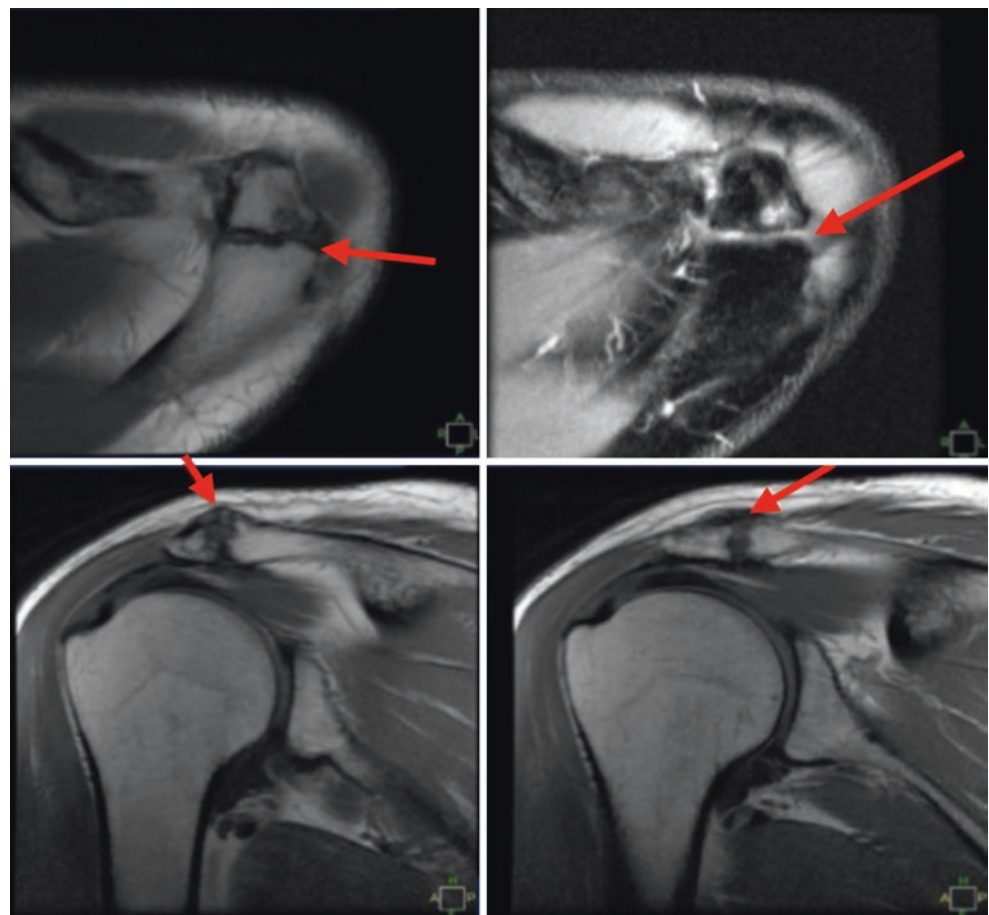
MRI left shoulder that shows an intact rotator cuff, healing of the previous SLAP repair, moderate AC joint osteoarthritis, and a meso-acromion with sclerotic changes and soft tissue swelling at the meso-acromion site. (Reproduced with permission from Stetson, W. B., Morgan, S., Chung, B., Hung, N., Mazza, G., McIntyre, A. Diagnosis and Treatment of the Meso-Acromion of the Shoulder. In: Amarasekera, H. W., editor. Recent Advances in Arthroscopic Surgery [Internet]. London: IntechOpen; 2018. Available from: <https://www.intechopen.com/chapters/60890>. <https://doi.org/10.5772/intechopen.76267>)
